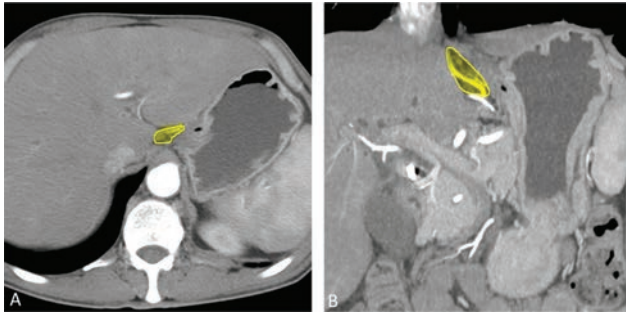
Station 1. Axial (A) and coronal (B) reformatted contrast enhanced computed tomography images in arterial phase showing first branch of ascending limb of left gastric artery (yellow area) along which station 1 nodes are expected in right paracardial location.
